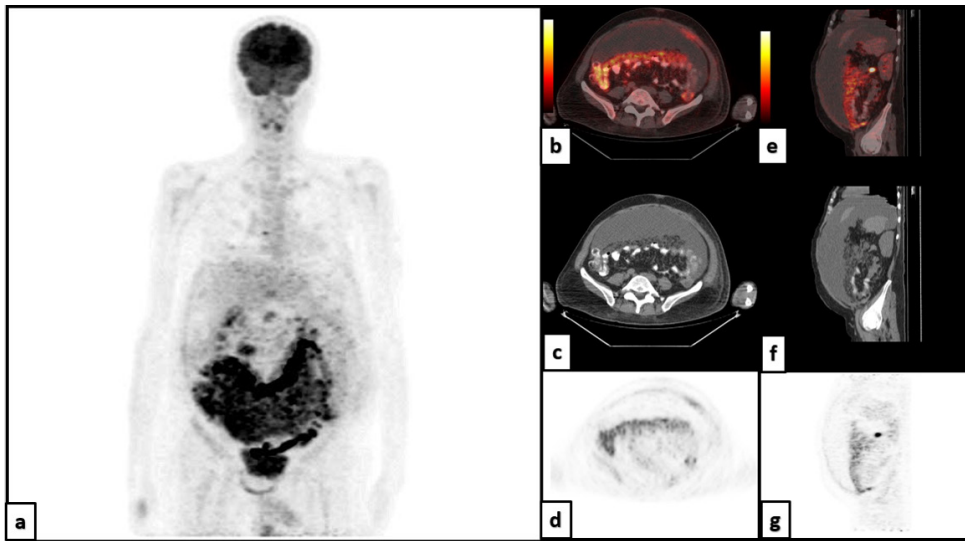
A 60-year-old man was admitted to the emergency department with progressive abdominal distention, and clinical assessment revealed the presence of ascites. Abdominal computed tomography showed peritoneal thickenings suggestive of peritoneal carcinomatosis. While undergoing gastro-colonoscopy and a testicular examination, the patient was referred to the nuclear medicine department for ^{18}F -fluorodeoxyglucose (^{18}F -FDG) positron emission tomography/computed tomography (PET/CT) and the radiology department for abdominal CT and magnetic resonance imaging (MRI) due to clinical suspicion of metastases. Maximum intensity projection (a) images, transaxial (b, c, d) sagittal (e, f, g) slices of fusion, and CT and PET/CT images of the abdomen showed multiple mild to moderate hypermetabolic nodular peritoneal thickening in the omentum and heterogeneity of the transverse mesocolon highly suggestive of peritoneal cancer with maximum standardized uptake value: 6.3. There was no other pathological finding in the rest of the body. True-cut biopsy was performed for the diagnosis and management of the therapy.
